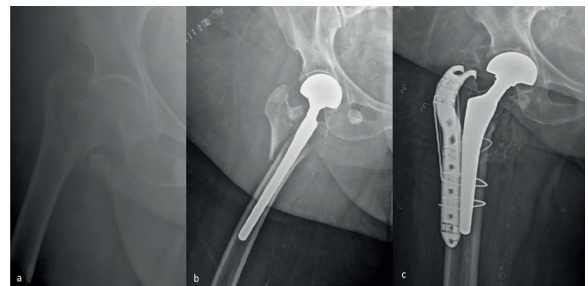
Radiographs of a 92-year-old woman with proximal femur fracture a) preoperative anteroposterior view b) early anteroposterior postoperative radiographs, postoperative fracture was around the greater trochanter c) periprosthetic femur fracture was reoperated and osteosynthesis was performed with trochanteric plates and cables
